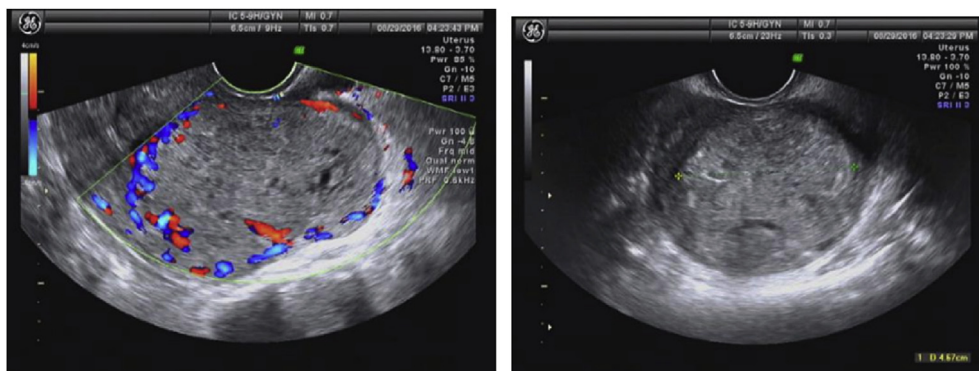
The ultrasonography showed an heterogenic mass with high blood flow and low resistance vascularity.
